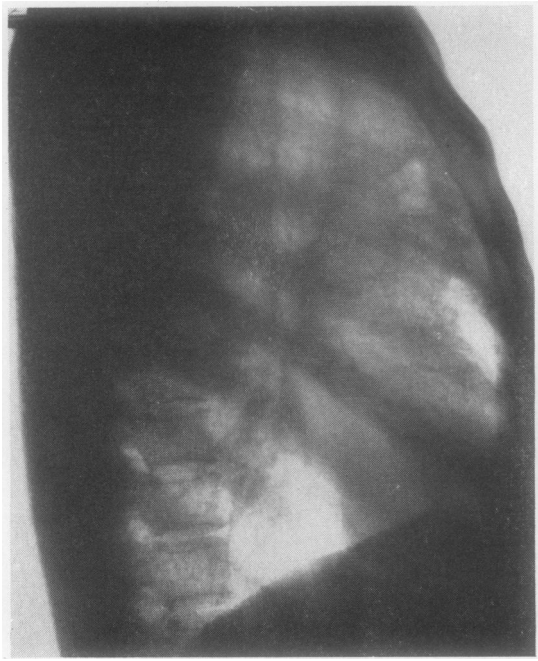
Lateral radiograph of Case 5 shows an oblong cavity with a small fluid level right behind the sternum.
